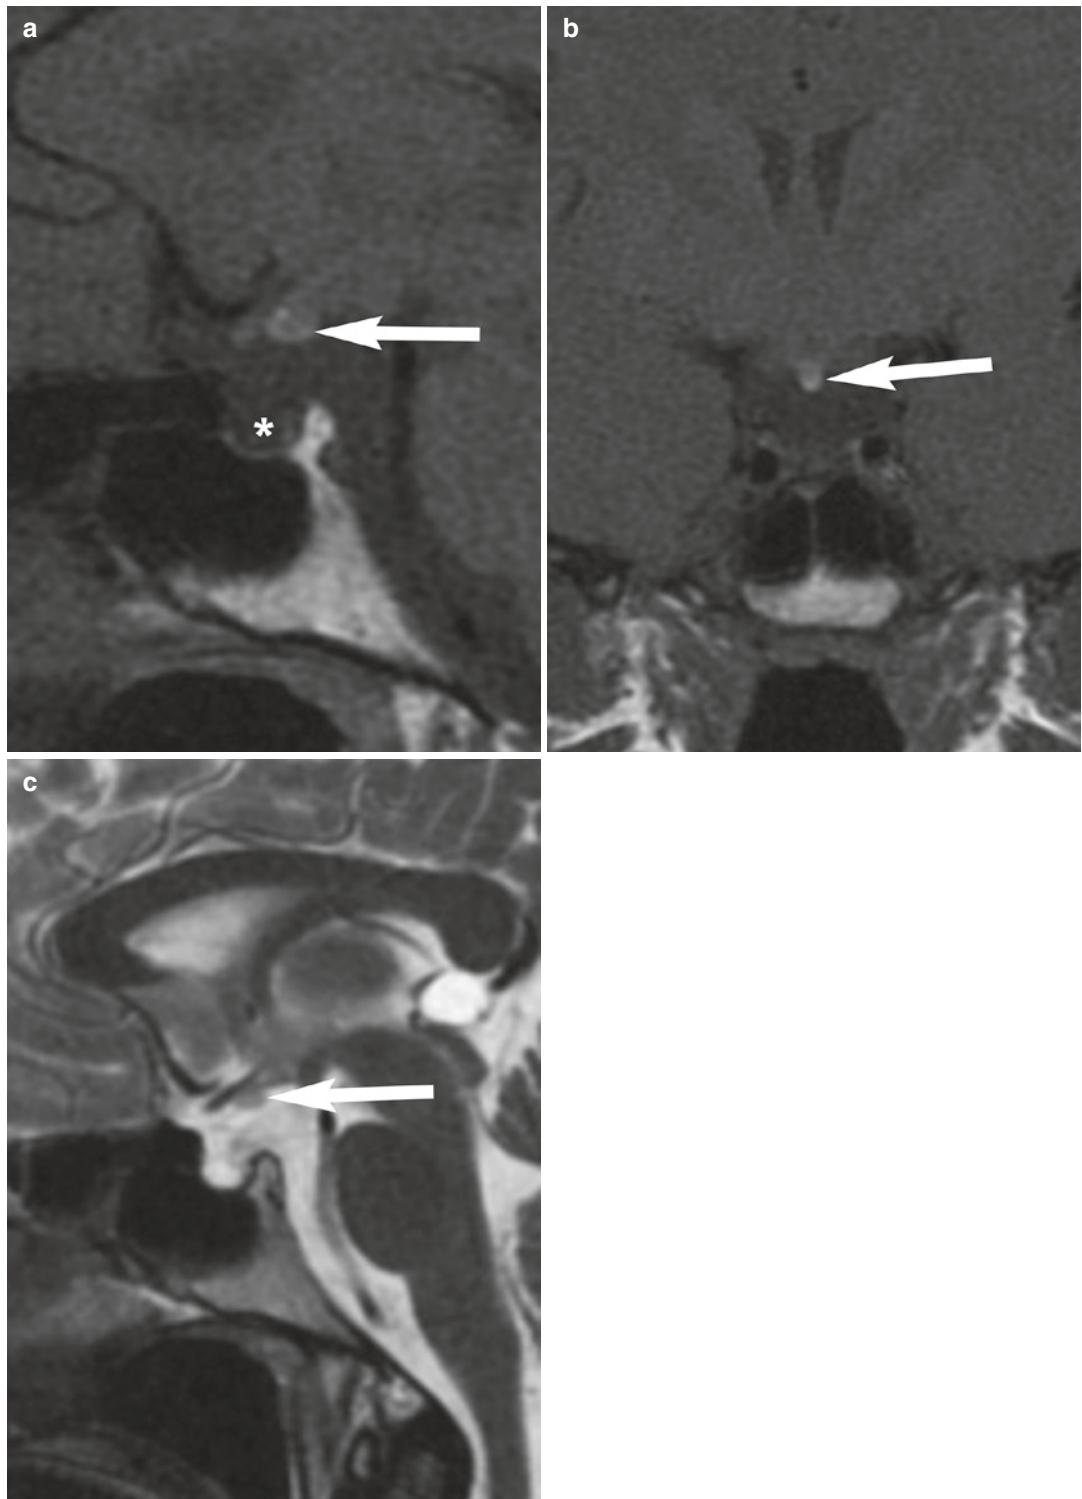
Congenital hormone deficiency. A 25-year-old male with panhypopituitarism. Sagittal unenhanced (a) and coronal unenhanced (b) T1-weighted and sagittal (c) T2-weighted MR images show absence of the pituitary
